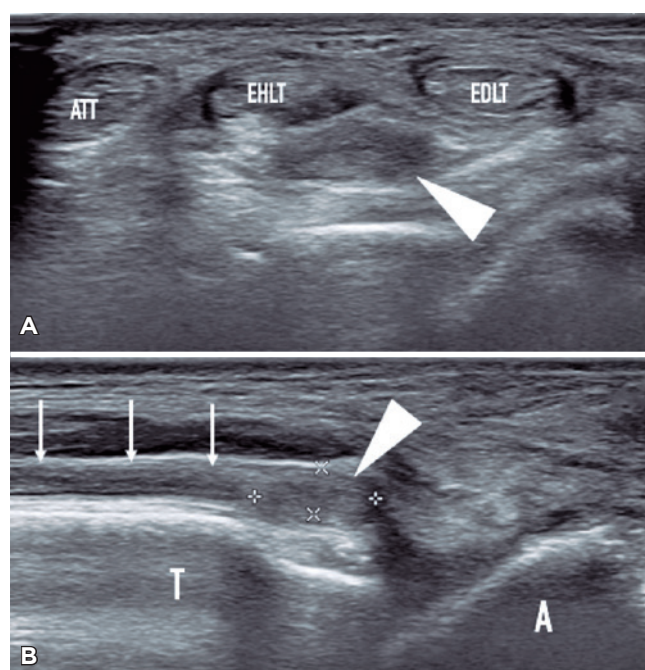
Ultrasonography showing a terminal neuroma. A) Axial plane. B) Longitudinal plane. White arrows mark the course of the deep peroneal nerve. Arrowheads mark the terminal neuroma.
